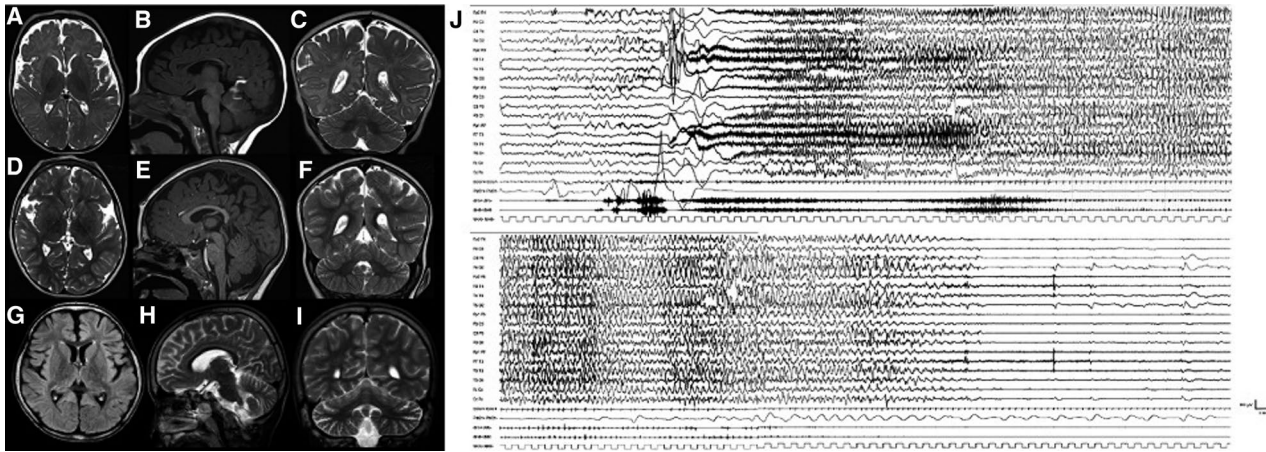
Brain MRI of Patients L and I (A-I), and ictal EEG of Patient L (J). Patient L at the age of 2 years 3 months (A-C) and 2 years 7 months (D-F): cerebral atrophy, with enlarged subarachnoid spaces around the frontal and insular lobes, without significant progression of the atrophy. Patient I at the age of 8 years (G-I): mild cerebral and cerebellar atrophy with enlarged subarachnoid spaces around the frontal and insular lobes and cerebellar folia. Ictal EEG of Patient L at the age of 42 days (J). Ictal discharge starts with diffuse bilateral, symmetrical, low-voltage fast activity, increasing in amplitude and decreasing in frequency. The patient has a massive tonic contraction with perioral cyanosis and sialorrhoea. Polygraphic recording shows ictal bradycardia at seizure onset for about 5 s concomitant with the beginning of the tonic phase (see bilateral contraction of upper limb in deltoids). Afterward, the patient appears floppy and pale associated with a brief compensatory tachycardia. The seizure spontaneously ends after 86 s
